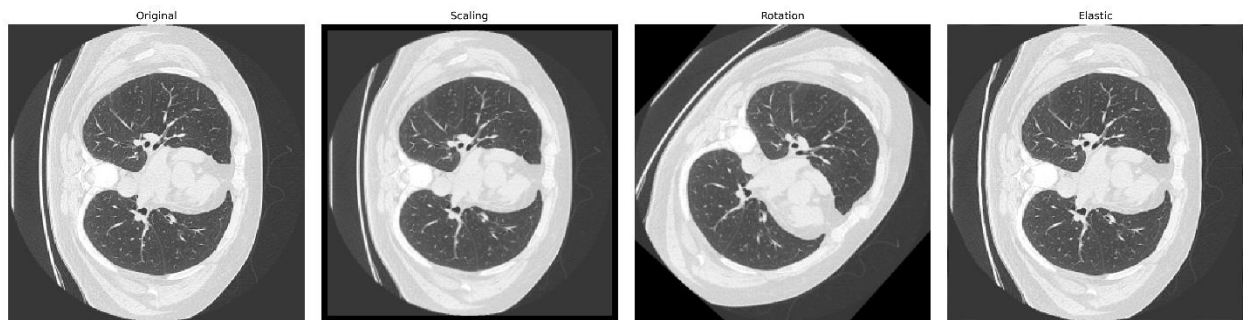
MRI lung data Augmentation with scaling, rotation, and elastic deformation.
